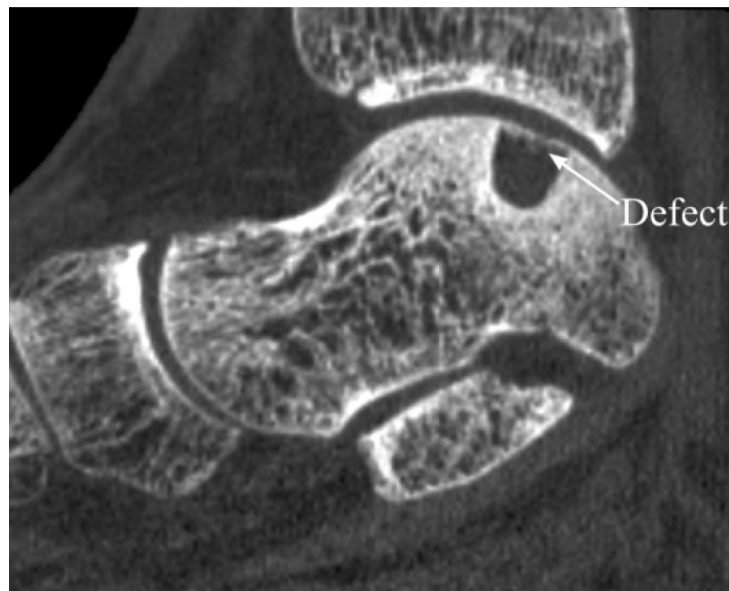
CT-scan of an osteochondral defect. A small lesion in the articular cartilage on the talar surface can erode to an osteochondral defect with bone loss as indicated by the arrow.
